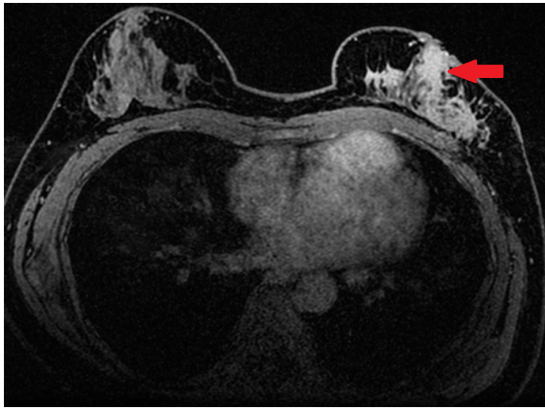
Initial breast magnetic resonance imaging image. The arrow indicates the location of the breast cancer lesion prior to treatment, which manifested as high signal intensity, with indistinct margins and nipple involvement.
